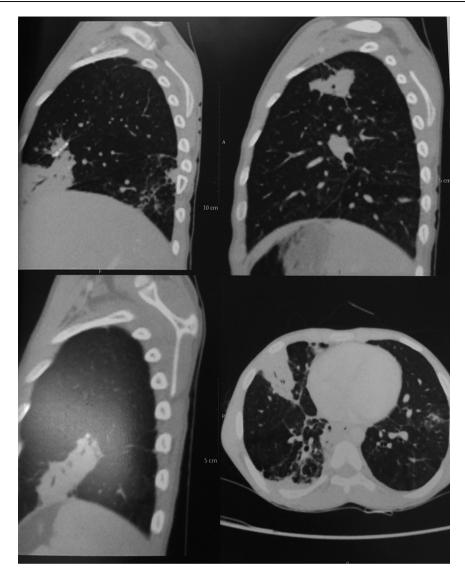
CT chest showing air bronchogram in right middle lobe, with partly necrotic nodes in subcarina, right hilar and pretracheal region.
